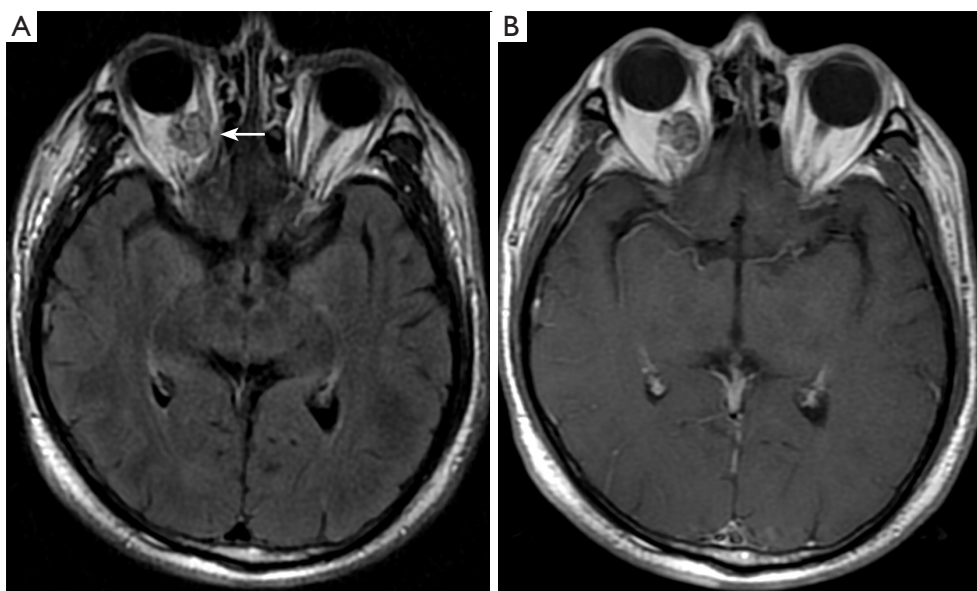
Blind spot in brain imaging: orbit. Scans of a 58-year-old male after surgery for adenocarcinoma of the left upper lung lobe. (A) MRI revealed the presence of an abnormal signal nodule in the right orbit (arrow), exhibiting mild and uneven enhancement on contrast-enhanced scans with clear boundaries. (B) Throughout the follow-up process, no distinct changes were observed, leading to the consideration of a benign condition, possibly a cavernous sinus hemangioma. MRI, magnetic resonance imaging.
